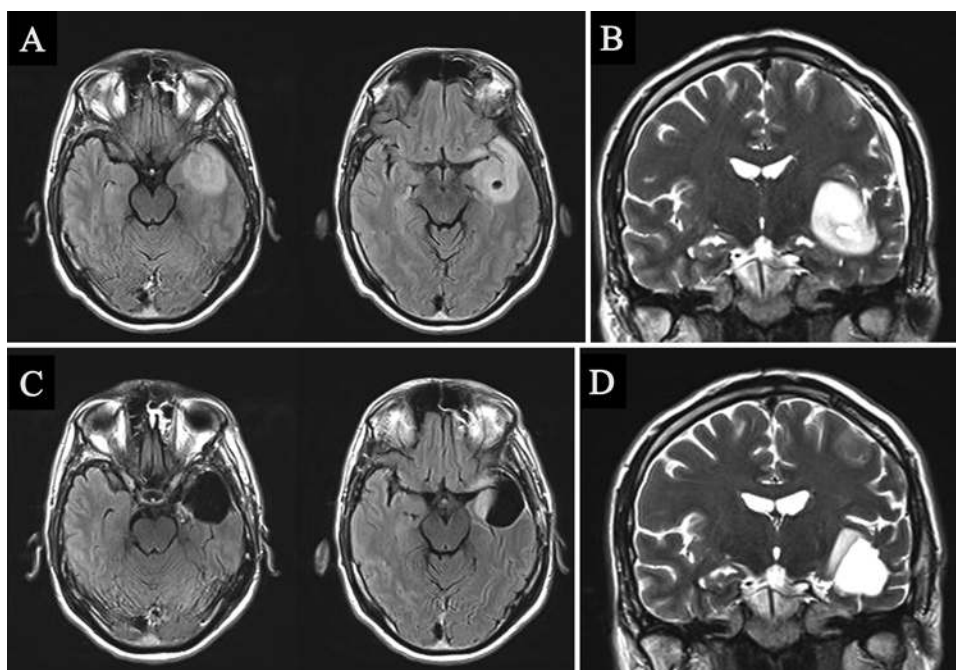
Preoperative axial (A) and coronal (B), and postoperative axial (C), and coronal (D) FLAIR images obtained in a patient who is still alive and undergoing simple surveillance at 60 months after the diagnosis of a left temporoparietal IDH-wt AII that was subtotally resected.
